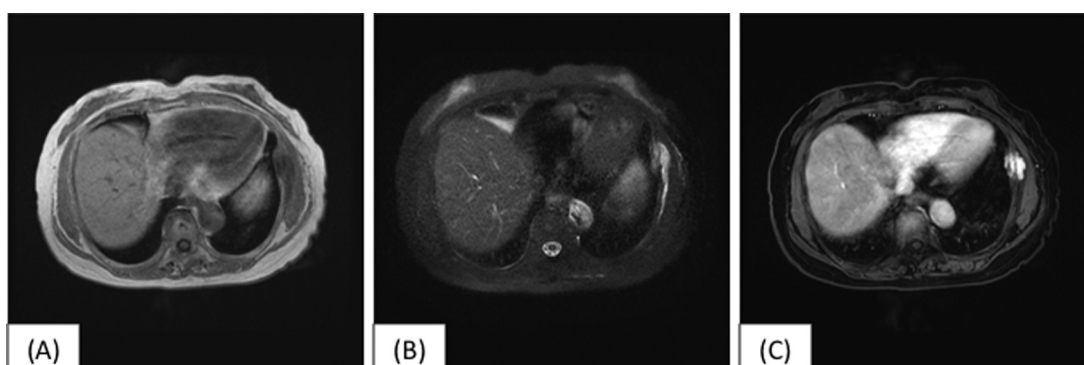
Magnetic resonance imaging showed (A) low signal intensity on T1-weighted images, (B) high signal intensity on T2-weighted images and (C) enhancement by contrast medium.
